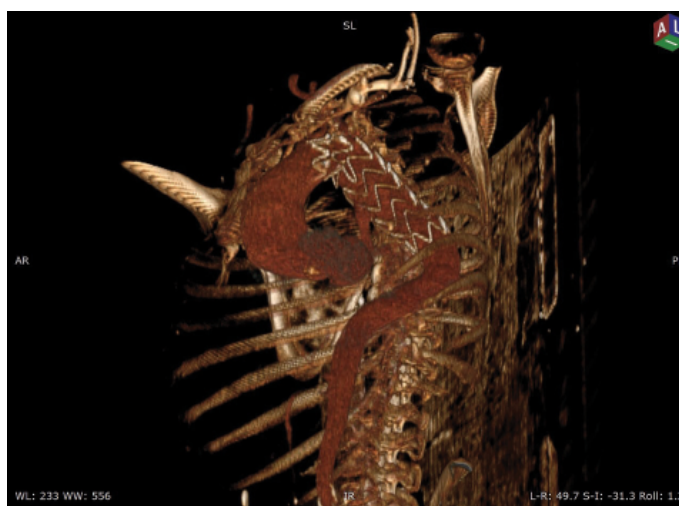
Postoperative CT angiographic view showing the stent graft within the descending aorta
